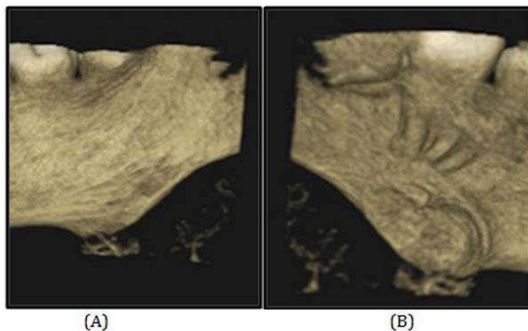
(A) Axial view (B) Saggital view of CBCT showing Radiopaque flecks arranged in concentric ring like pattern.
